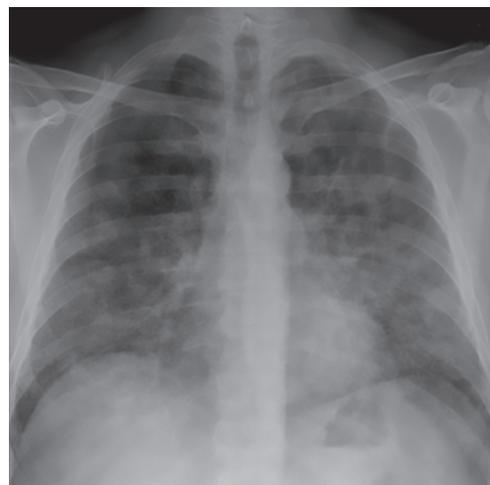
Chest X-ray in pulmonary alveolar proteinosis
